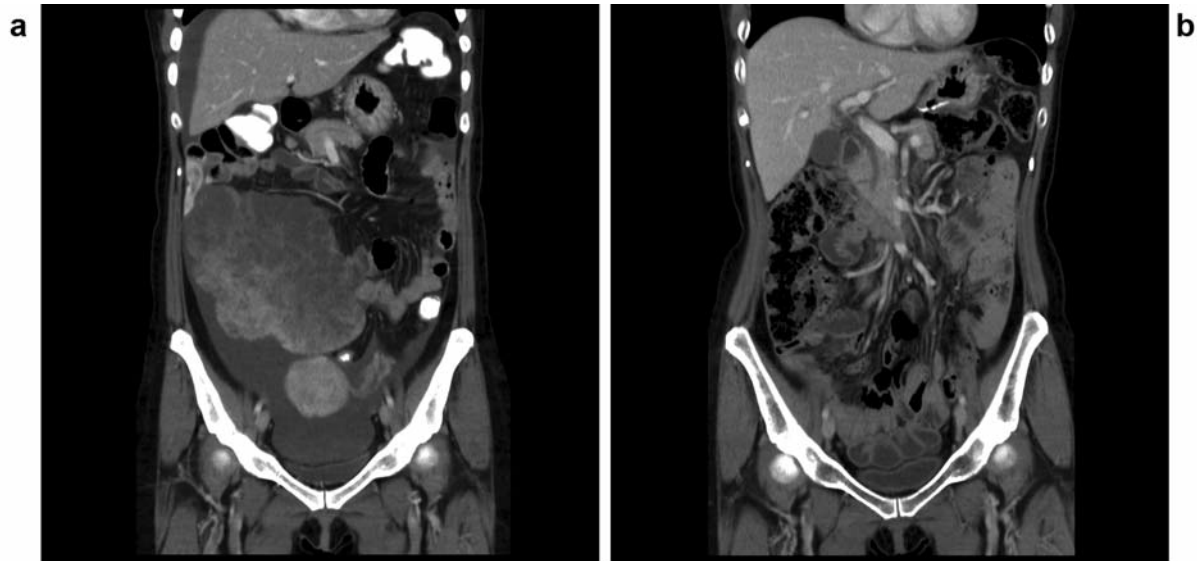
a: Computed tomographic scans of a 51-year-old woman with presentation of bulky pelvic masses and ascites. b: The patient remained disease-free for four years after metastasectomy of Krukenberg tumors plus subtotal gastrectomy, and postoperative chemotherapy.
